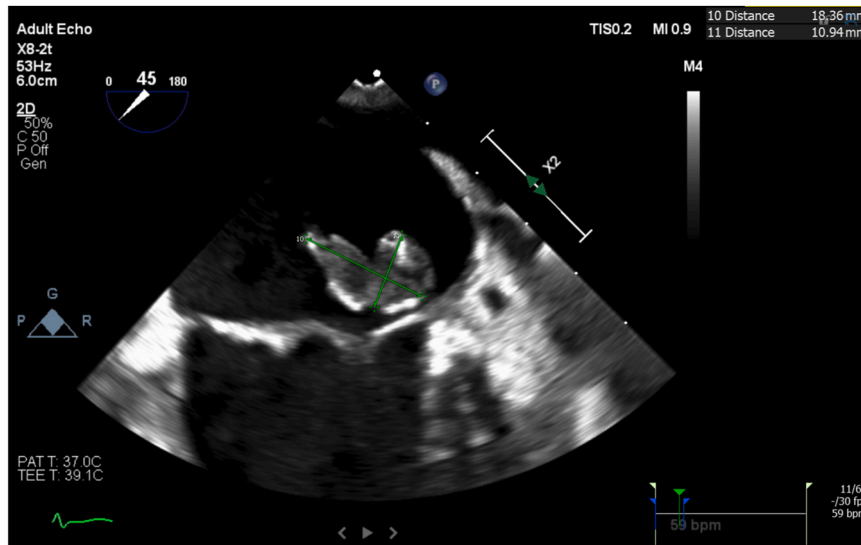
Transthoracic echocardiogram depicting a 1.8 × 1.1 cm vegetation (thin green arrows) on the atrial surface of the posterior leaflet of the mitral valve.
